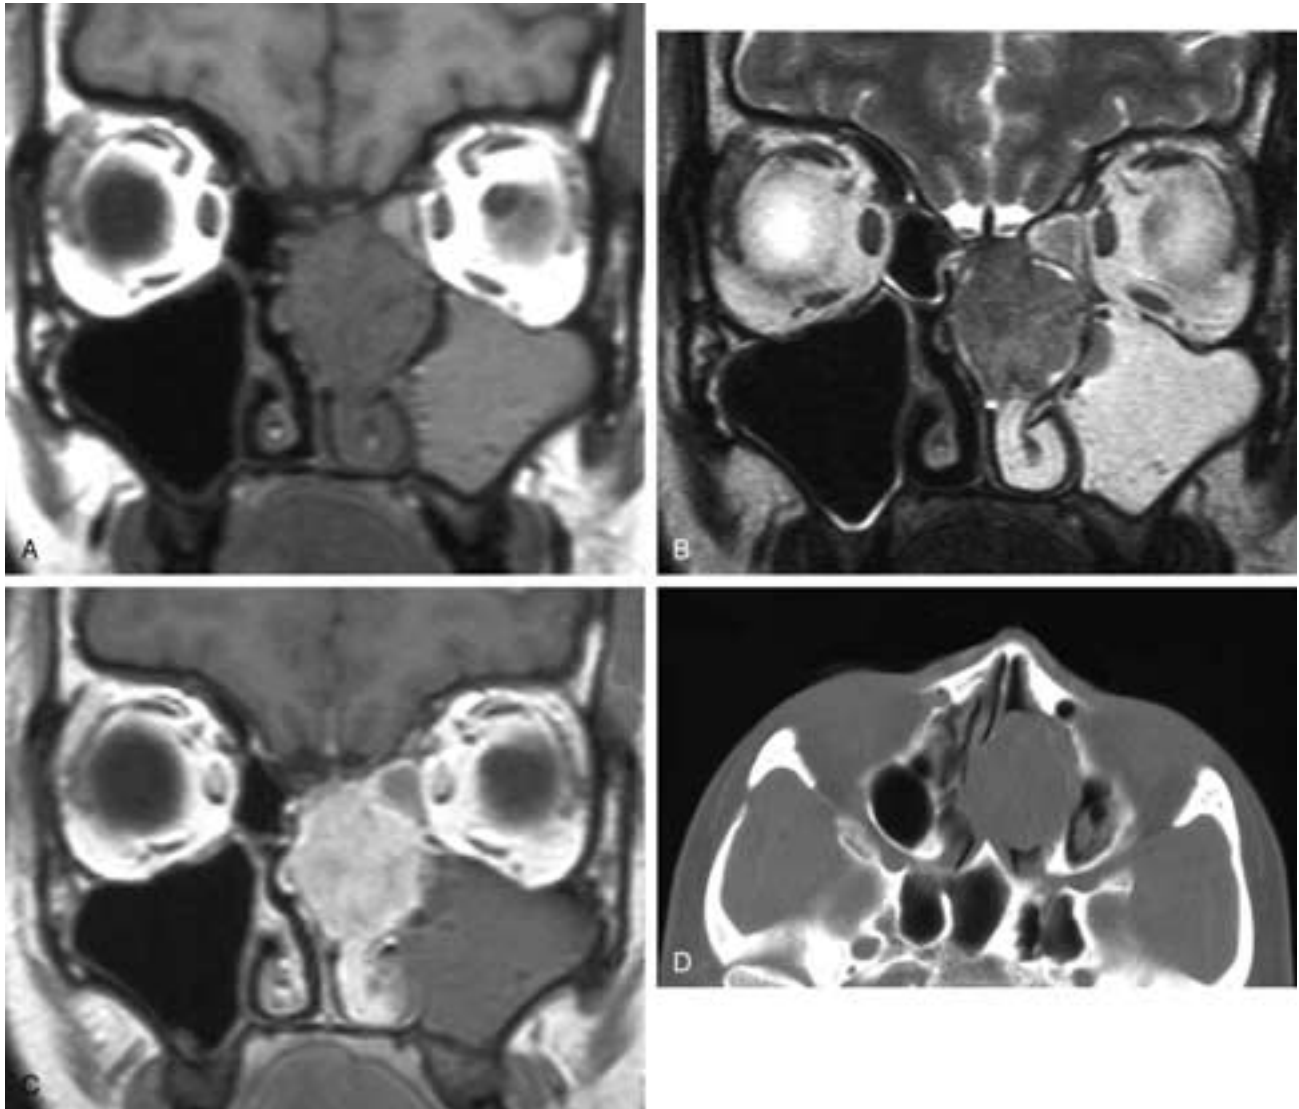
Coronal T1-weighted (A), T2-weighted (B), and T1-weighted, fat-suppressed, contrast-enhanced (C) MR images and an axial CT scan (D) show a spherical noninvasive mass in the upper left nasal fossa. The mass obstructs the remaining left ethmoid cells and the left maxillary sinus. The mass has a low T1- and T2-weighted signal intensity, and it enhances. The spherical shape suggests that this is either a minor salivary gland tumor or a lesion such as a schwannoma. This was a clear cell tumor metastatic from renal cell carcinoma.
